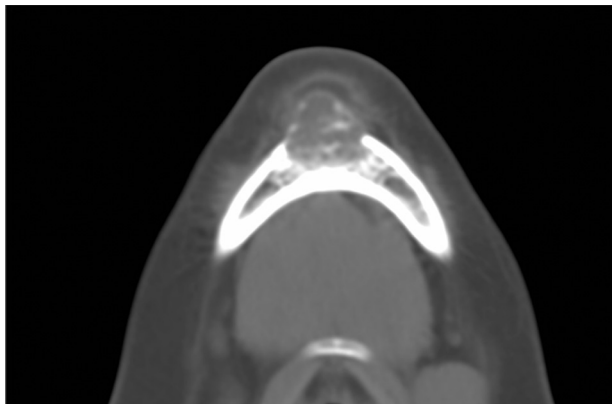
Radiograph demonstrating giant cell tumor of the jaw in a 13-years-old man with HPT-JT syndrome and parathyroid carcinoma. HPT-JT, hyperparathyroidism-jaw tumor syndrome.
